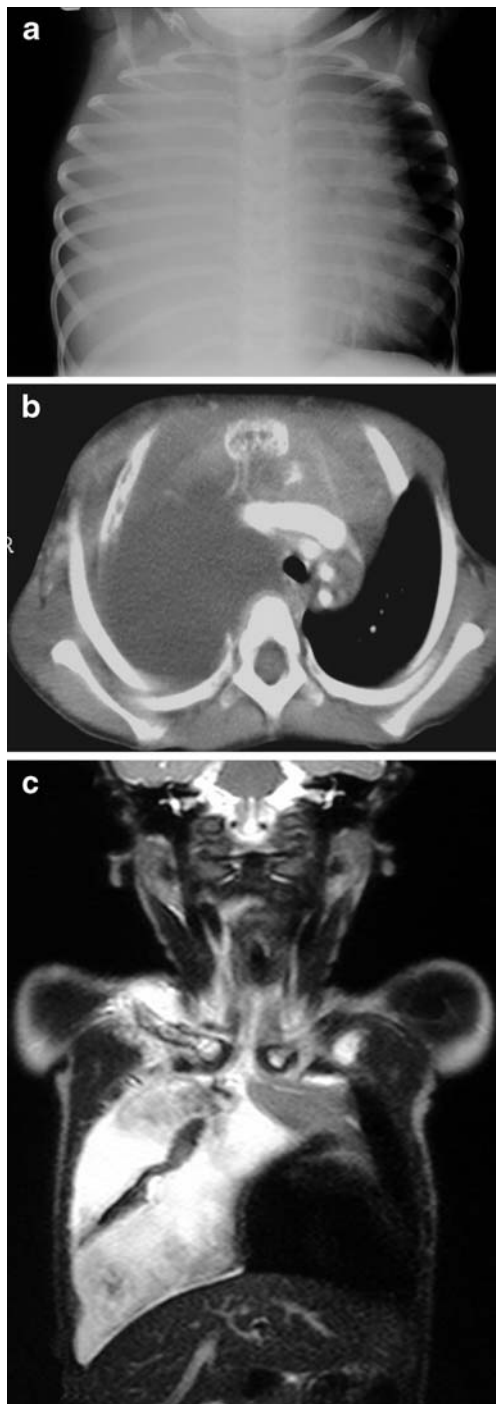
Gorham disease in a 2-year-old boy with respiratory distress. (a) AP chest radiograph shows a dense lesion in the entire right hemithorax with the mediastinum displaced to the left and bone lesions. The right clavicle contains a sclerotic/lytic lesion, and the first two right ribs have an altered bone trabecula pattern. (b) Axial CT scan shows the lytic bone lesion in the sternum and the first right rib. A pleural effusion is occupying the right hemithorax and a soft-tissue lesion is seen in the chest wall. (c) Coronal T2-W MR image shows an enlarged, hyperintense right clavicle with soft tissue involvement and a large ipsilateral pleural effusion. The results of open surgical biopsy of the clavicle were consistent with bone lymphangiomatosis
